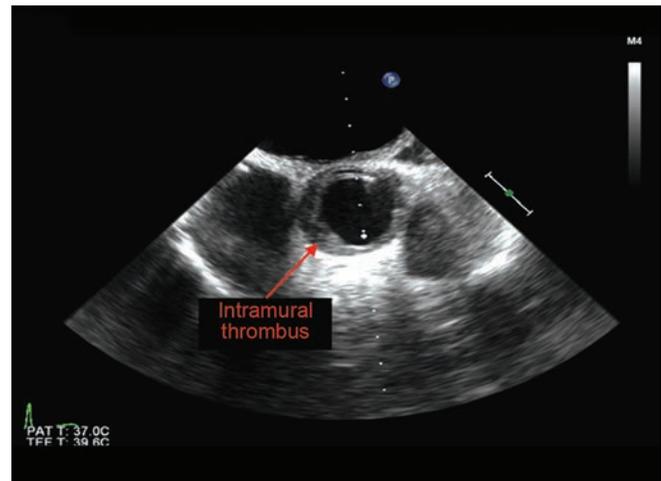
Transesophageal echocardiography (TEE) showing a cross-sectional view of the ascending aorta.
